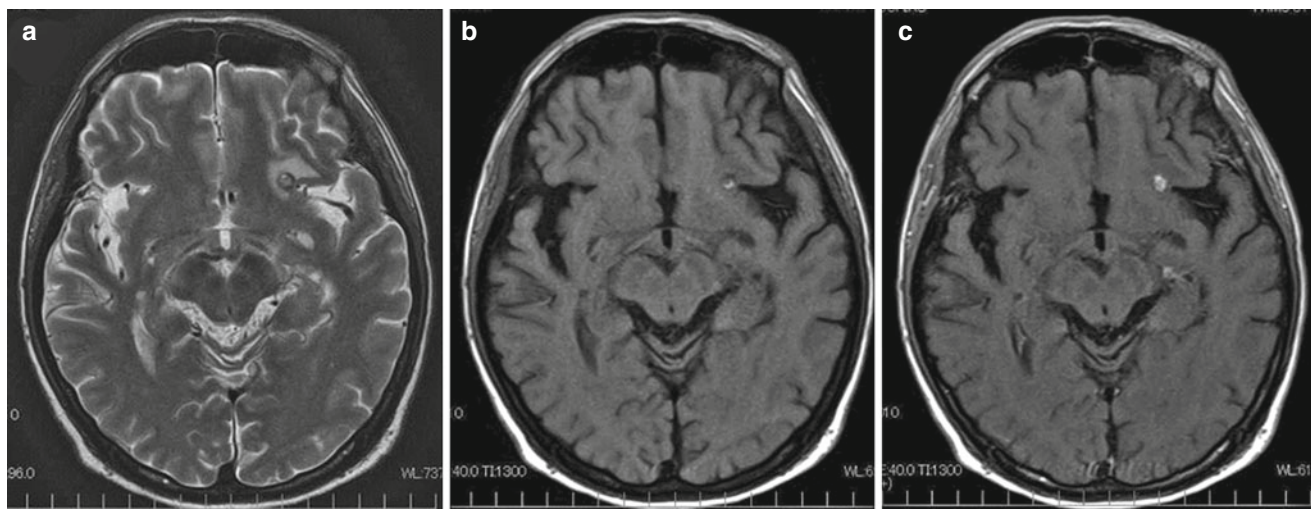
Brain metastasis of lung adenocarcinoma with previous small intralesional hemorrhage, which appears as a low intensity signal on T2-weighted (a) and high intensity signal on precontrast T1-weighted
